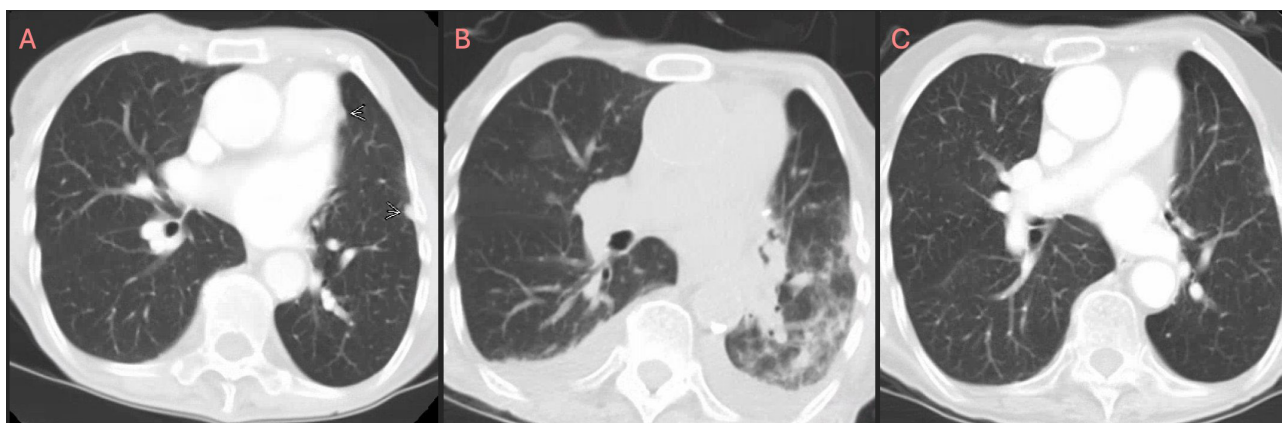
A) Initial CT chest showing left-sided peripheral pleural nodule indicative of a metastatic focus; B) CT chest showing left lower lobe consolidation consistent with pneumonia along with small bilateral pleural effusions due to alectinib; C) Follow-up imaging 7 months after stopping alectinib showing resolution of left lower lobe consolidation and bilateral pleural effusions.
